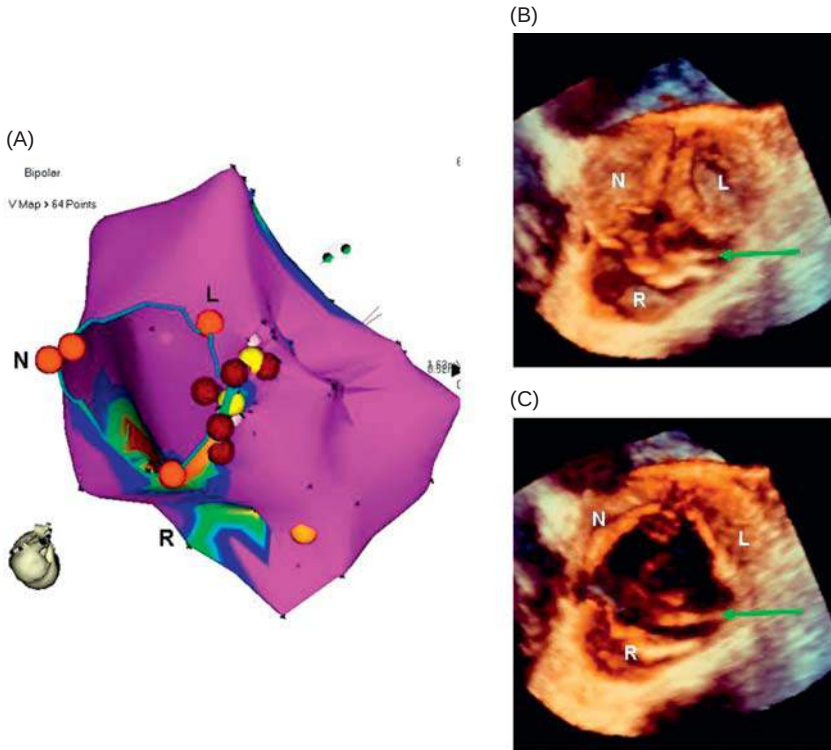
(A) A coronal view of an electroanatomic voltage map. The right and left cusps (orange tags) as well as the noncoronary cusp (N) are displayed. Normal voltage (color purple: >1.5 mV) was noted without scar. Successful ablations were performed at the commissure between the right and the left cusps. (B) Images from the 3D transesophageal echocardiogram with a coronal view of the aortic valve during diastole when the valves are closed. The aortic cusps are designated as right (R), left (L), and noncoronary cusp (N). The arrow depicts the ablation catheter beneath the valve plane with the cusps coapted. The catheter tip is located at the commissure between the right and the left aortic cusps. (C) The same view of the aortic valve plane during systole when the cusps are opened
